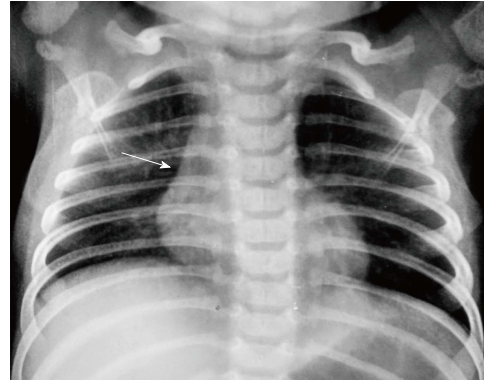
Frontal chest radiograph of a 2-year-old boy showing the inferior margin of the thymus merging with the cardiac silhouette - the "notch sign" (arrow).
